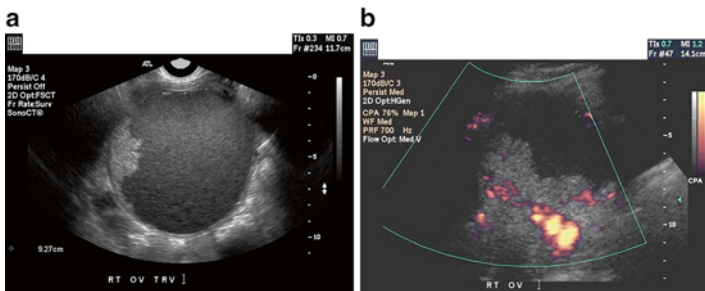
Ovarian cancer. (a) A solid excretion is present on the inner cyst wall of this complex ovarian cyst. (b) Doppler examination of the mass reveals multiple intermediate resistance vessels. A stage I-C epithelial ovarian cancer was found at laparotomy (Reprinted from Cohen [62], Figure. 4a, b, with kind permission from Springer Science and Business Media)
